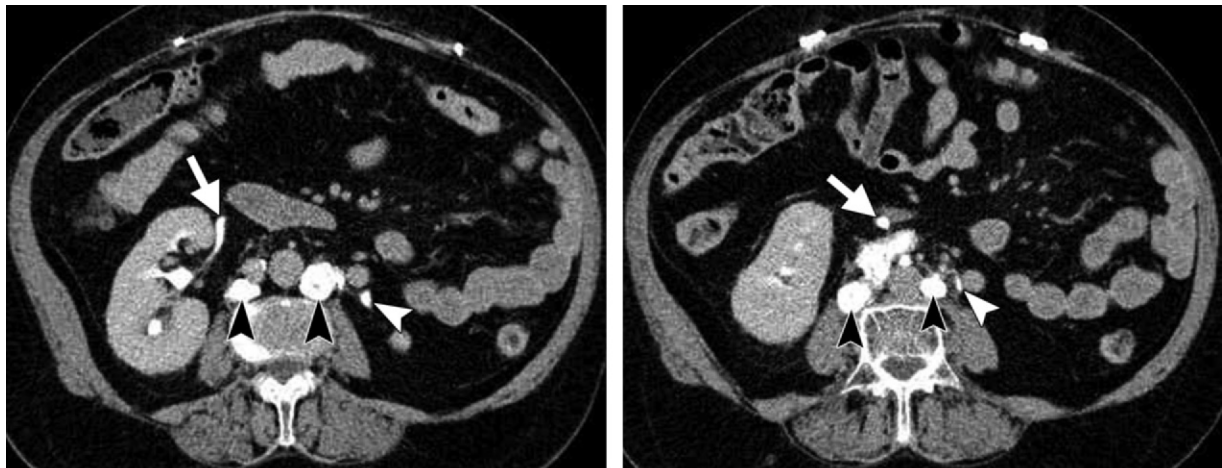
Surgical treatment for obstructive uropathy secondary to idiopathic RPF. Axial CT images (a) at a higher level than (b) obtained 180 seconds after contrast material administration show intraperitonealization of the right ureter (arrow). Note the periaortic mass with calcifications (black arrowheads), which contacts but does not encase the left ureter (white arrowhead) on its way through the retroperitoneum. (Case courtesy of Aleksandar Radosevic, MD, Hospital del Mar, Barcelona, Spain.)
